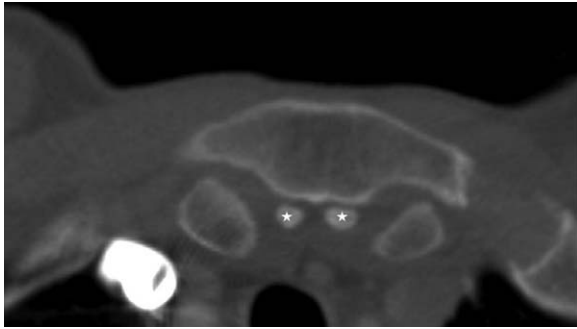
CT image of the sternal ossicle in the axial plane (stars)
